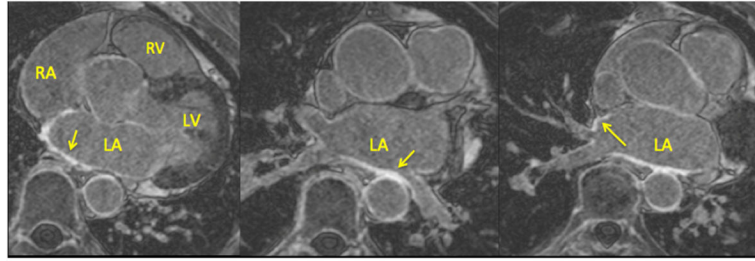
Sample axial MR images showing the left atrial wall late-gadolinium enhancement at the site of scar
